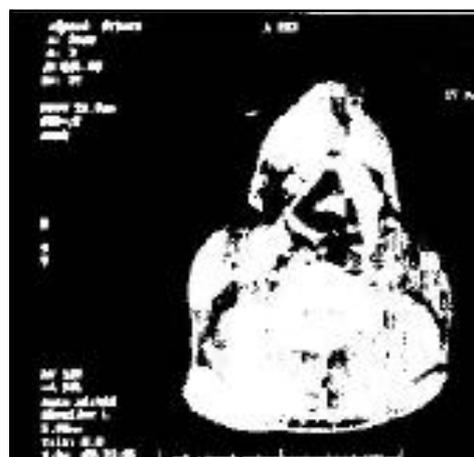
Axial CT scan of the neck shows edematous tissue in the vallecular region extending to the epiglottis and left aryepiglottic fold.
